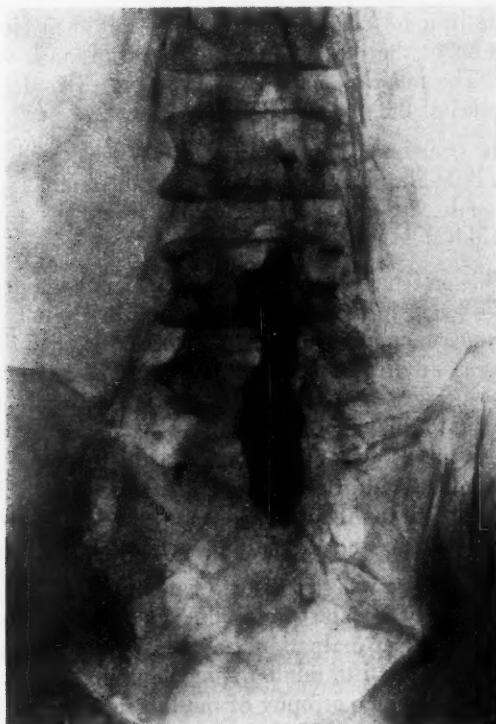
Roentgenogram showing deformity in column of lipiodol characteristic of protruded intervertebral disc between the fourth and fifth lumbar vertebrae.
